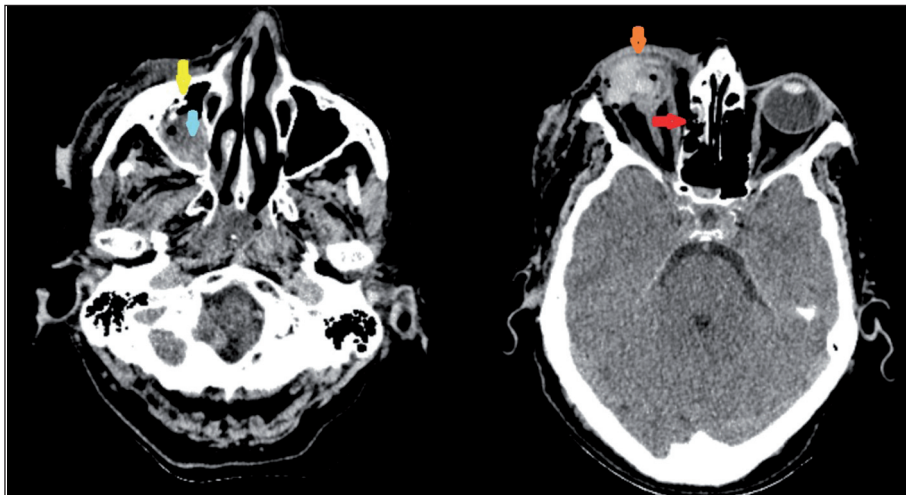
CT scans showed fragmented fractures at medial (red arrow) and inferior (yellow arrow) walls in the right eye (blow out fracture), right maxillary sinus hematoma (blue arrow) rupture and collapse of the globe and intraocular hemorrhage (orange arrow).
